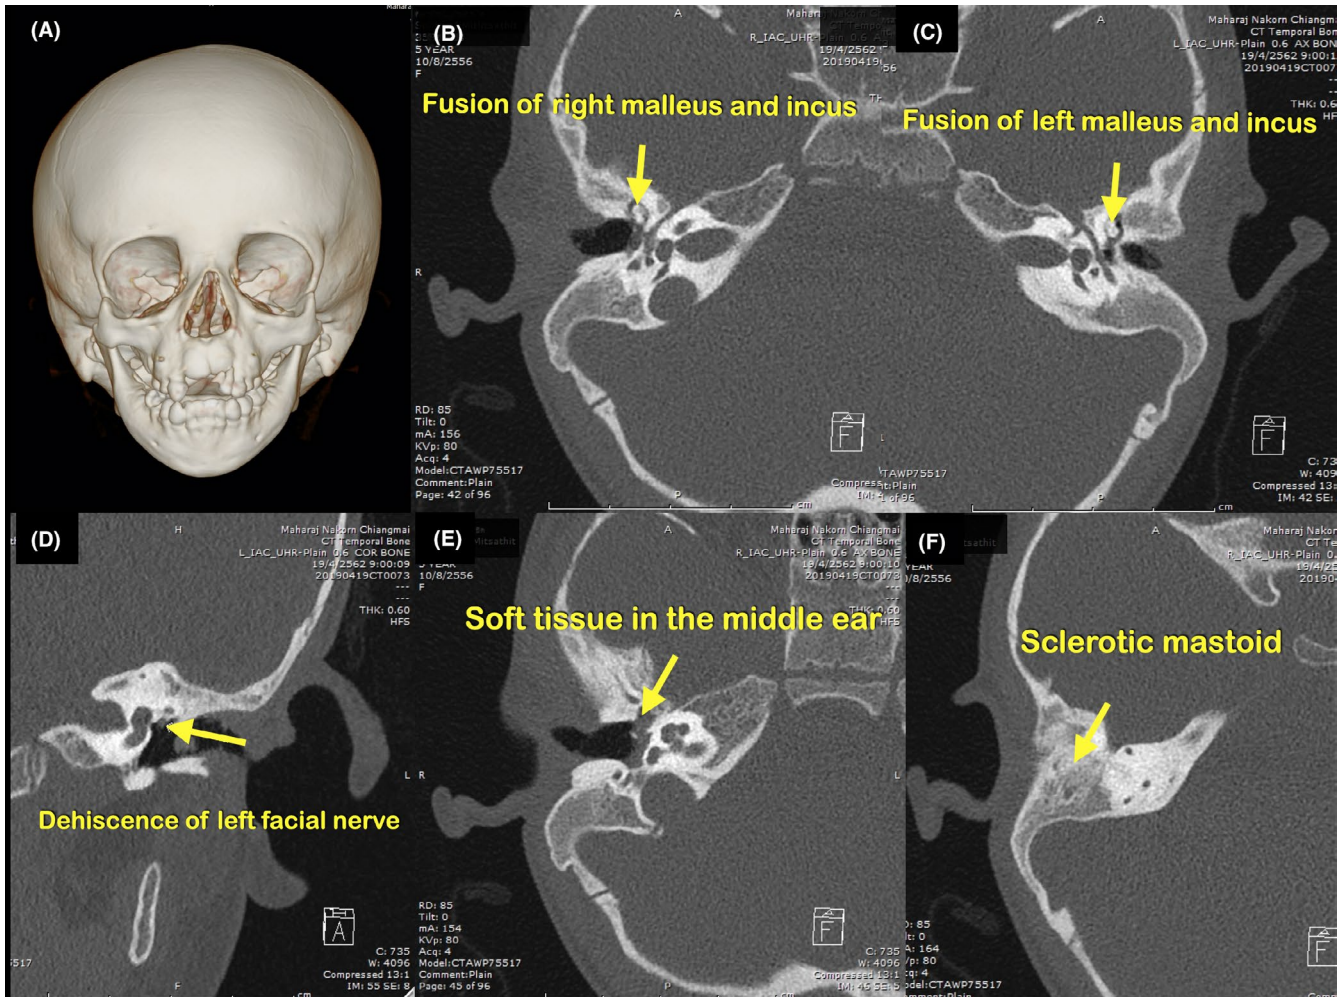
Computed tomograms of Patient III-3 at age 4 years. (A) Skull with mildly narrow zygomatic bones (B) Fusion of right malleus and incus. (C) Fusion of left malleus and incus. (D) Dehiscence of tympanic part of left facial nerve. (E) Hypoplasia of right middle ear cavity with partial opacification. Soft tissue remnant in the right middle ear. (F) Non-pneumatized mastoid air cells of right ear
